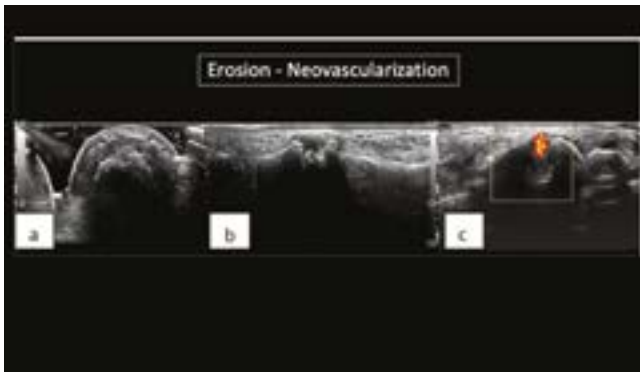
Bone erosion – Short axis (a) and longitudinal (b) image of the carpal bone shows erosion, which has a power doppler signal (c) suggesting active erosion with neovascularisation
